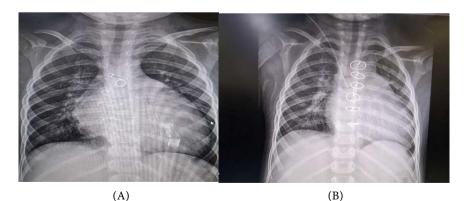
X-ray of the chest from the front. (A) Preoperative; (B) Postoperative.
